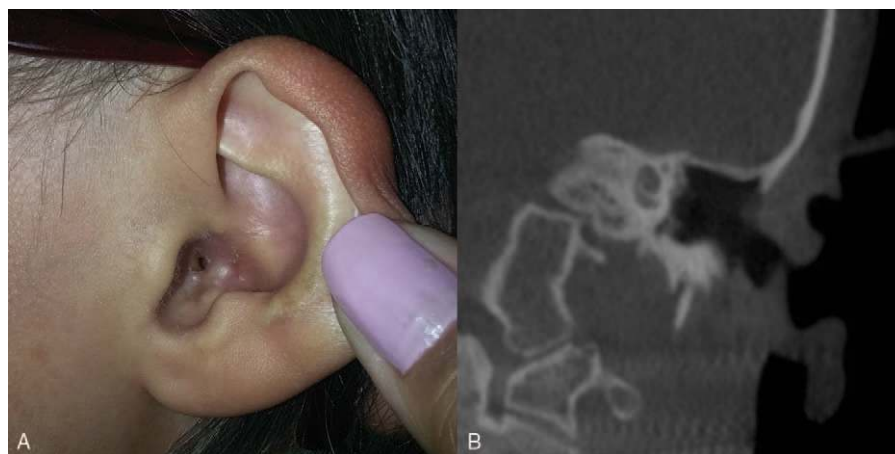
Postoperative external auditory canal stenosis. (A) Left ear. (B) CT study of left temporal bone.
